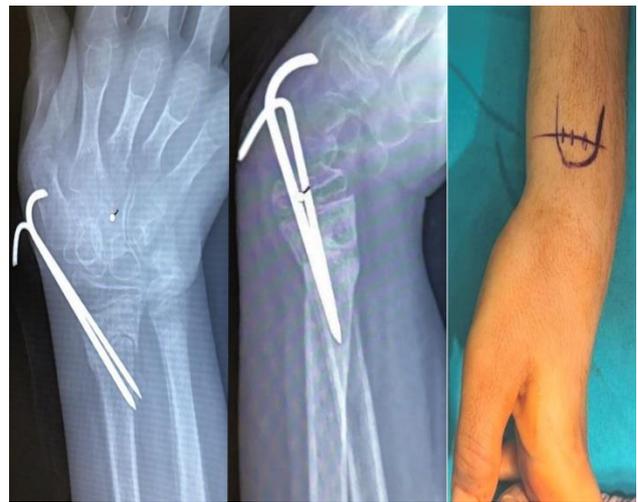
Image of intraoperative marking of the transverse mini-incision. Early postoperative AP and L radiographs
